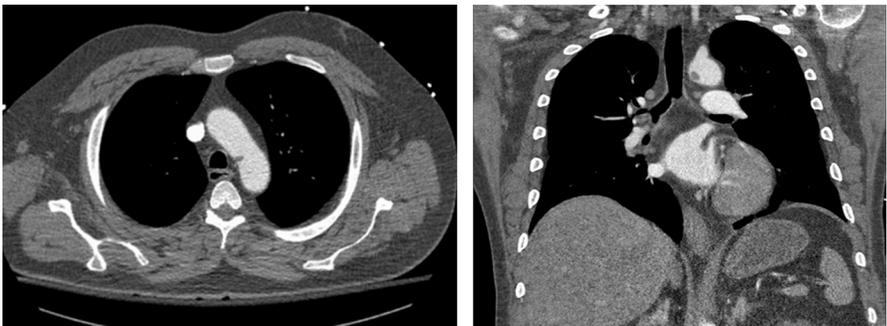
Axial (*left*) and coronal (*right*) slices of a thoracic CT scan demonstrating a small thoracic aortic lesion after patient fall. Note that this lesion is in the classic location, adjacent to the left subclavian takeoff (seen best in the coronal slice).
